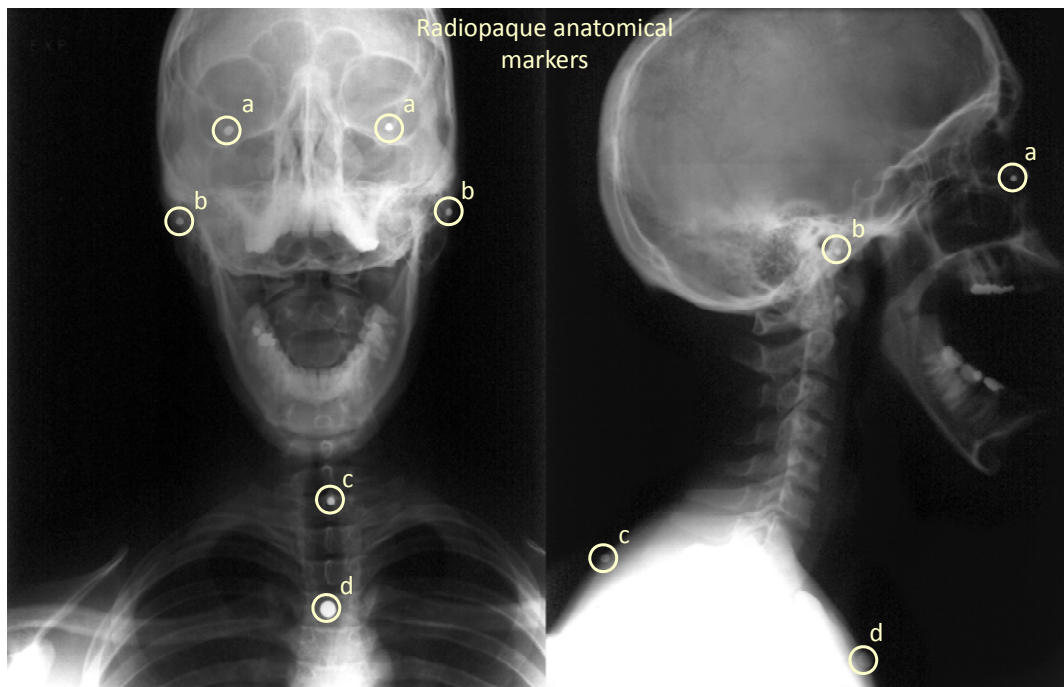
Anterior-posterior and lateral anthropometry X-rays were taken simultaneously. Lead markers, which appear as white dots, are attached to the (a) infraorbital notches, (b) auditory meatus, (c) instrumentation mount, and (d) suprasternal notch (Francis, 1991).
